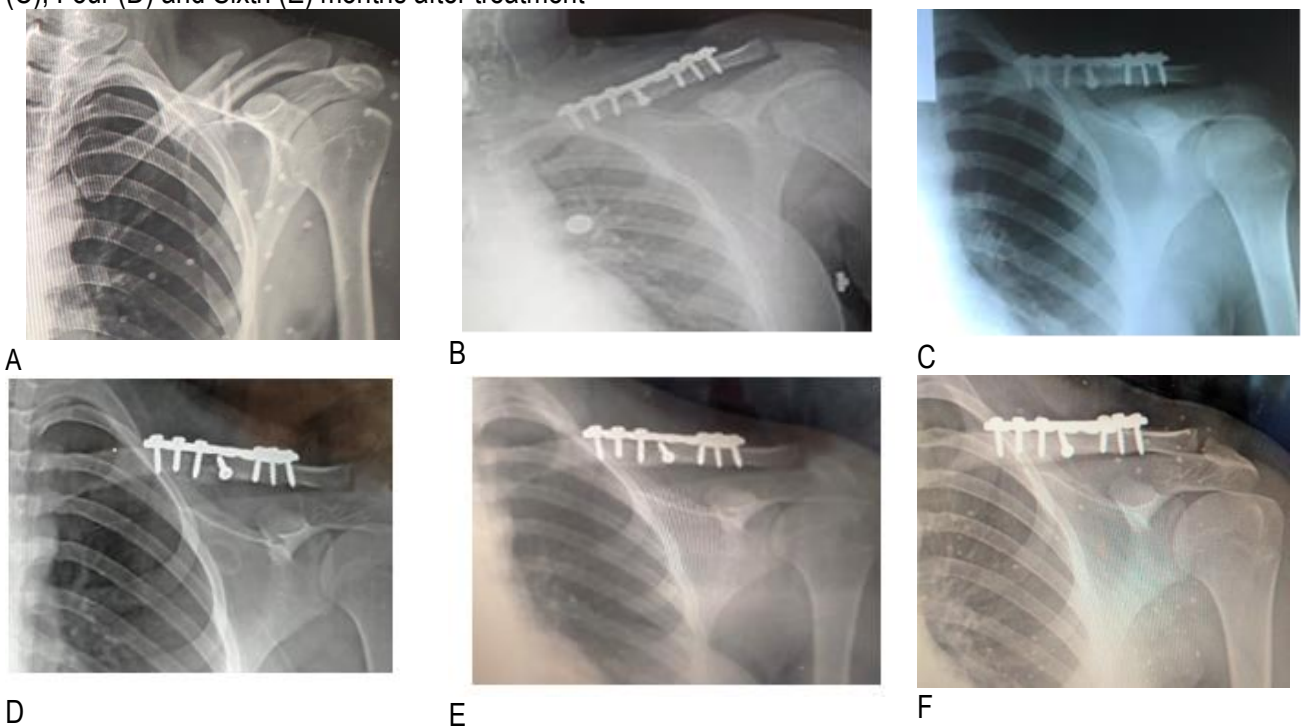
The second patient treated by plate fixation: here are the x-rays: preoperative (A), Four days (b), One month (C), two months (D) four months (E) and six months (F) after treatment
